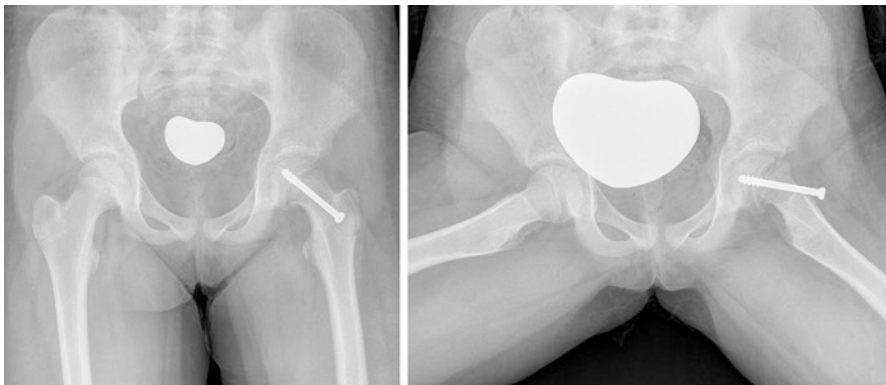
AP and frog lateral plain radiographs demonstrating in situ fixation of a left-sided SCFE in a 12 year old
